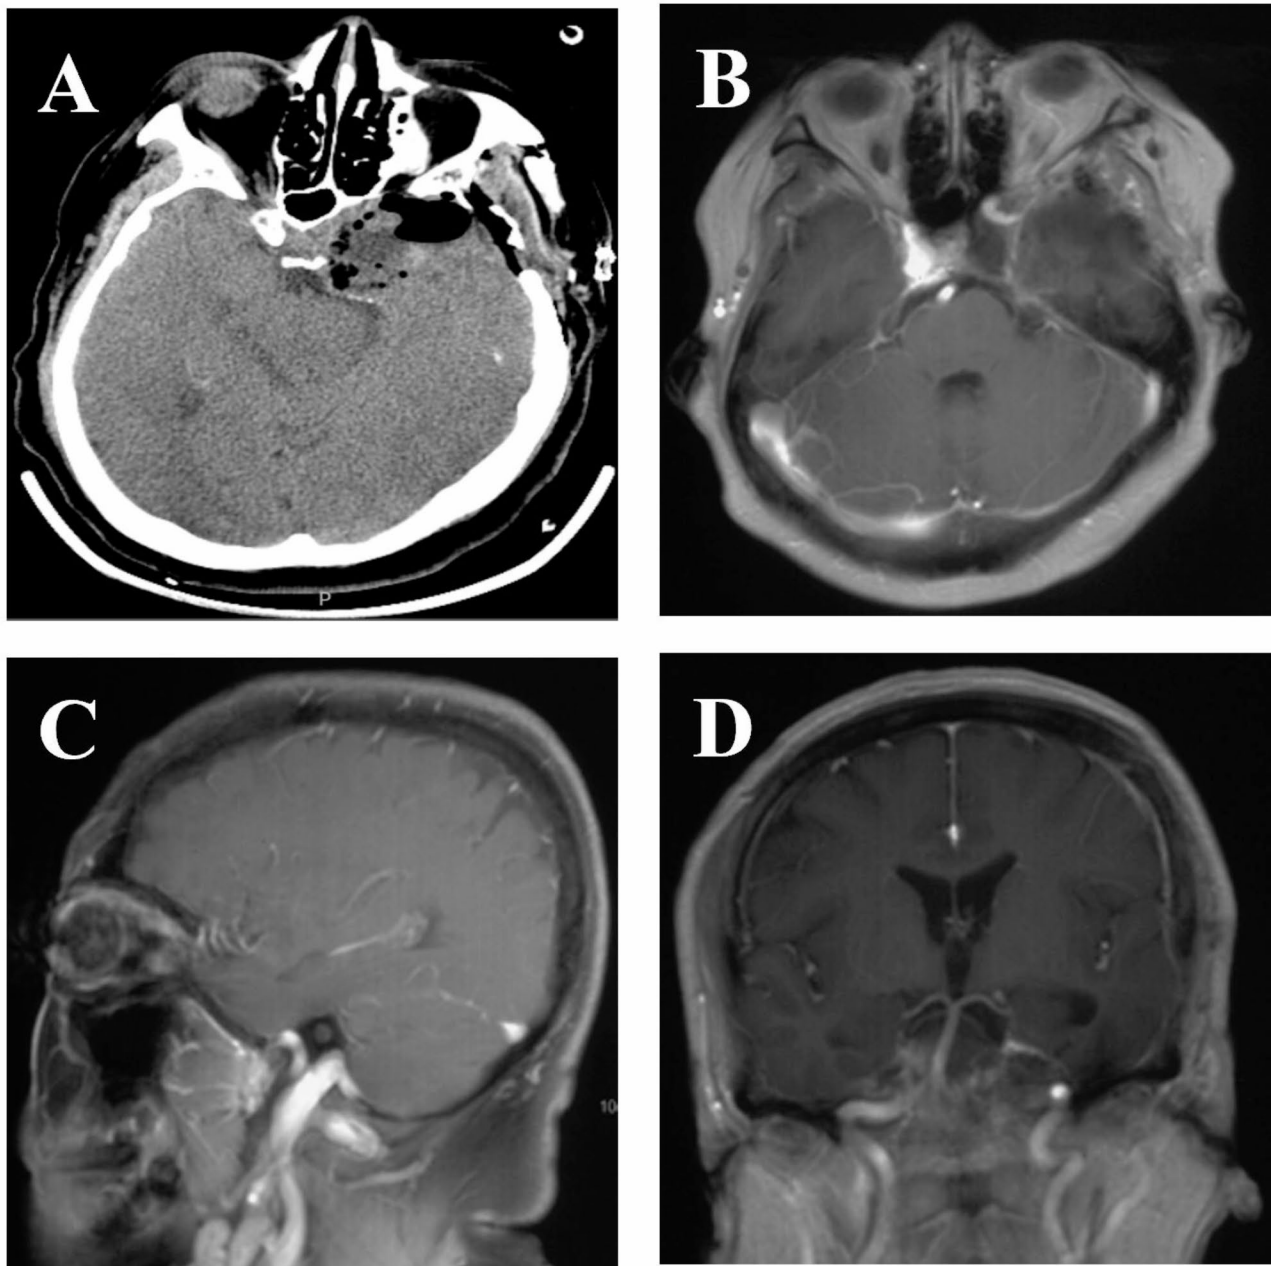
Postoperative imaging. A: CT-scan showed that the tumor had been completely resected at the first postoperative day; B-D: Postoperative gadolinium-injection enhanced MRI showed that no recurrence of the tumor was found in 8 mo after surgery; E: Postoperative DWI showed no cerebral infarction at 8 months after operation
